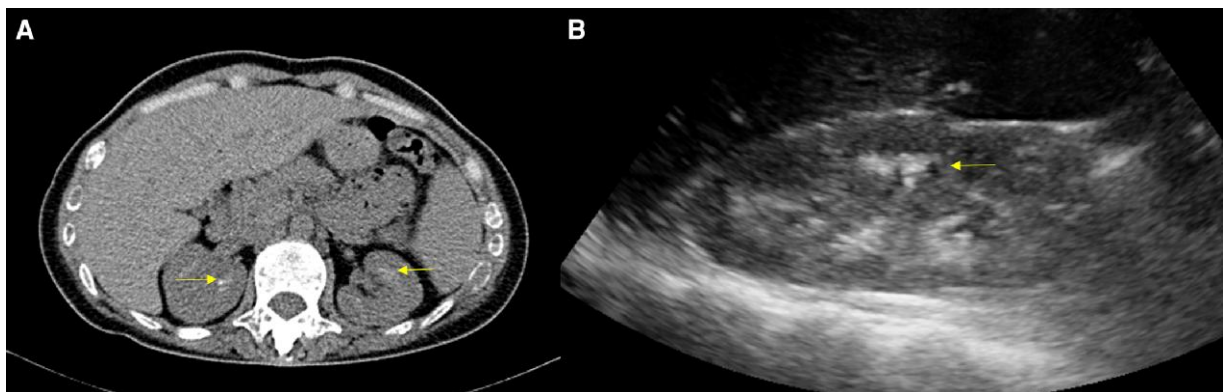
Genitourinary CT and renal ultrasonography findings. (A) Axial CT image demonstrating bilateral medullary nephrocalcinosis with renal calyceal stones (arrows). (B) Renal ultrasonography showing increased echogenicity in both kidneys, consistent with medullary nephrocalcinosis (arrow).
